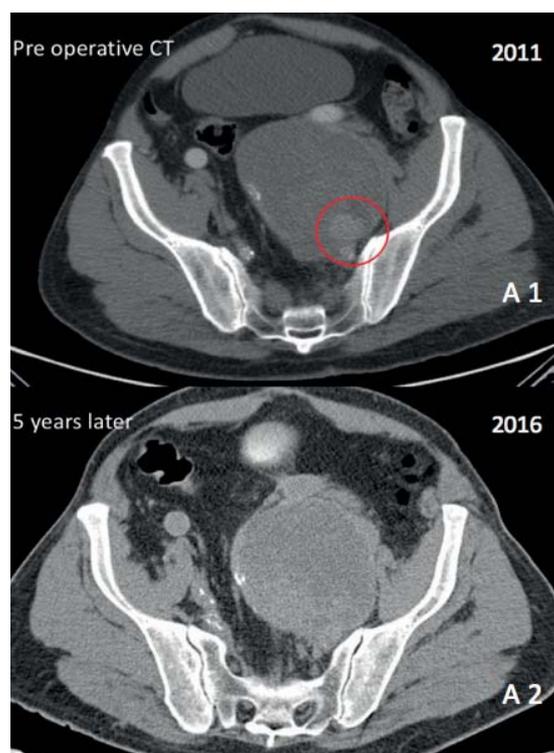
pre-operative CT; Figure 2 Follow-up CT five years later
